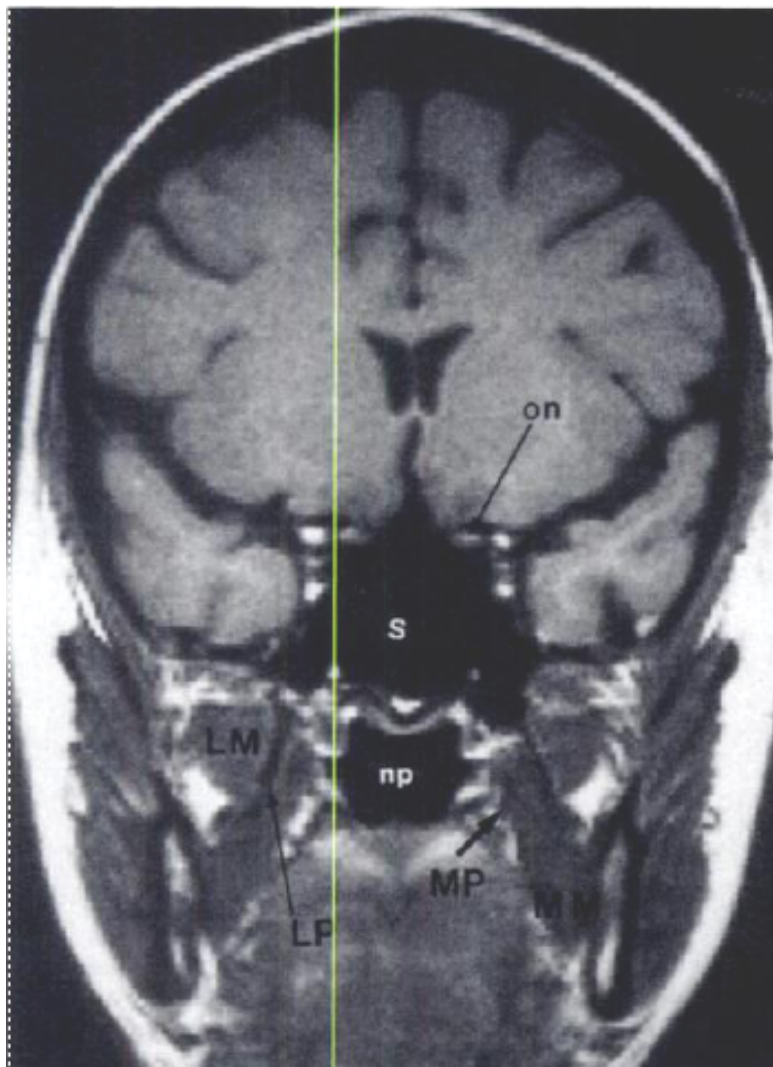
Coronal T1-weighted MR images of the skull base arranged from anterior (a) to posterior (d). *C* = clivus, *ca1* = cervical portion of carotid artery, *ca2* = petrous portion of carotid artery, *ca4* = cavernous portion of carotid artery, *ca5* = supraclinoid portion of carotid artery, *i* = pituitary infundibulum, *ld* = lateral dural reflection of cavernous sinus, *LM* = lateral pterygoid muscle, *LP* = lateral pterygoid plate, *MM* = medial pterygoid muscle, *MP* = medial pterygoid plate, *np* = nasopharynx, *och* = optic chiasm, *on* = optic nerve, *pg* = pituitary gland, *pof* = petrooccipital fissure, *S* = sphenoid sinus, *V3* = mandibular branch of trigeminal nerve in foramen ovale, *V* = trigeminal nerve.
